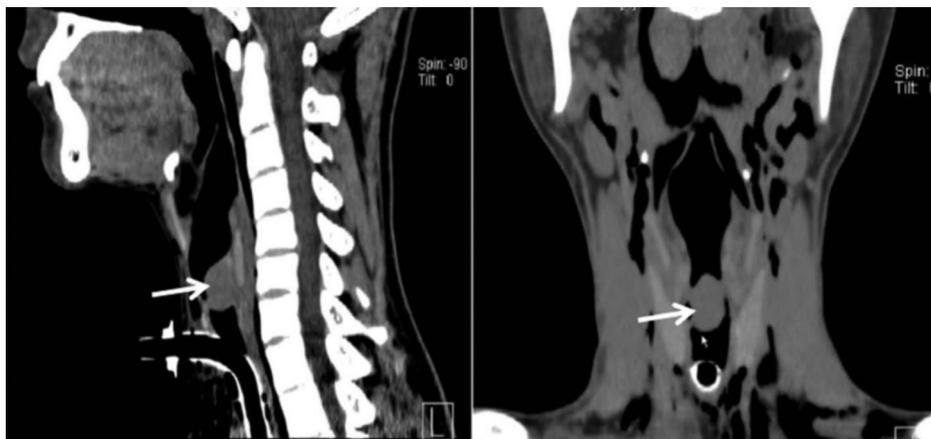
Neck computed tomography showed a 1.5 × 1.0 cm oval subglottic tumor arising from the posterior wall of the upper trachea.
